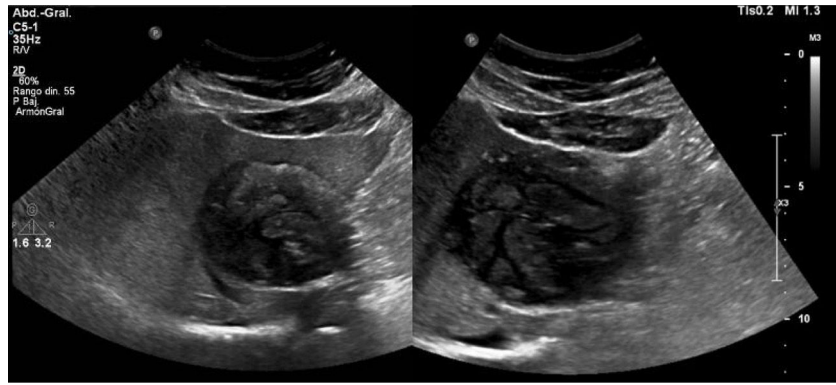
Complementary liver ultrasound study was performed.
